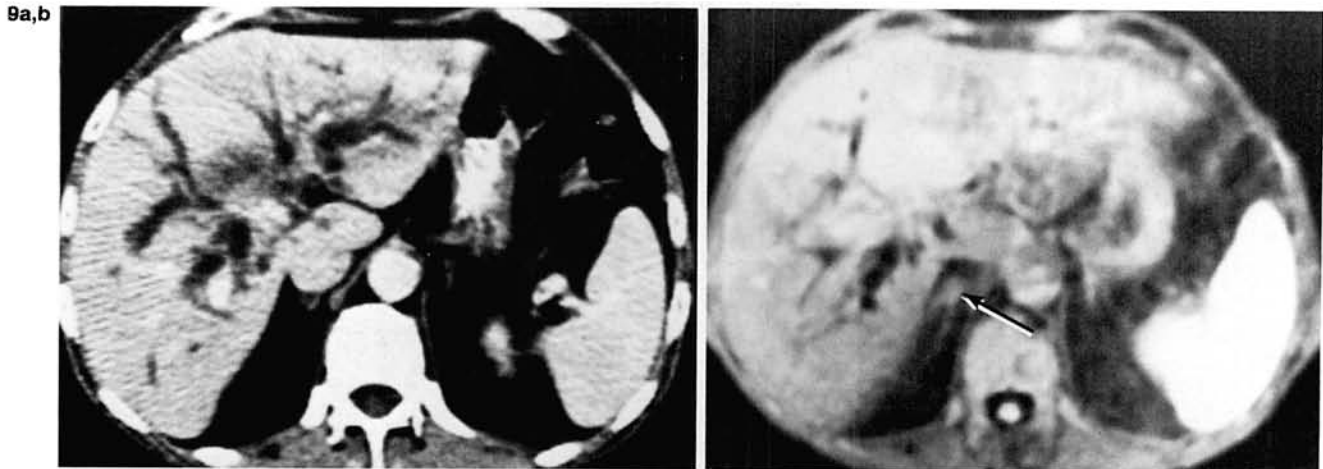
Metastases from carcinoma of the colon: contrast enhanced CT (a) and double inversion recovery (DIR)_{3,000/1,200/100/44} (b) scans. Note the adrenal metastasis in (b) (arrow).
